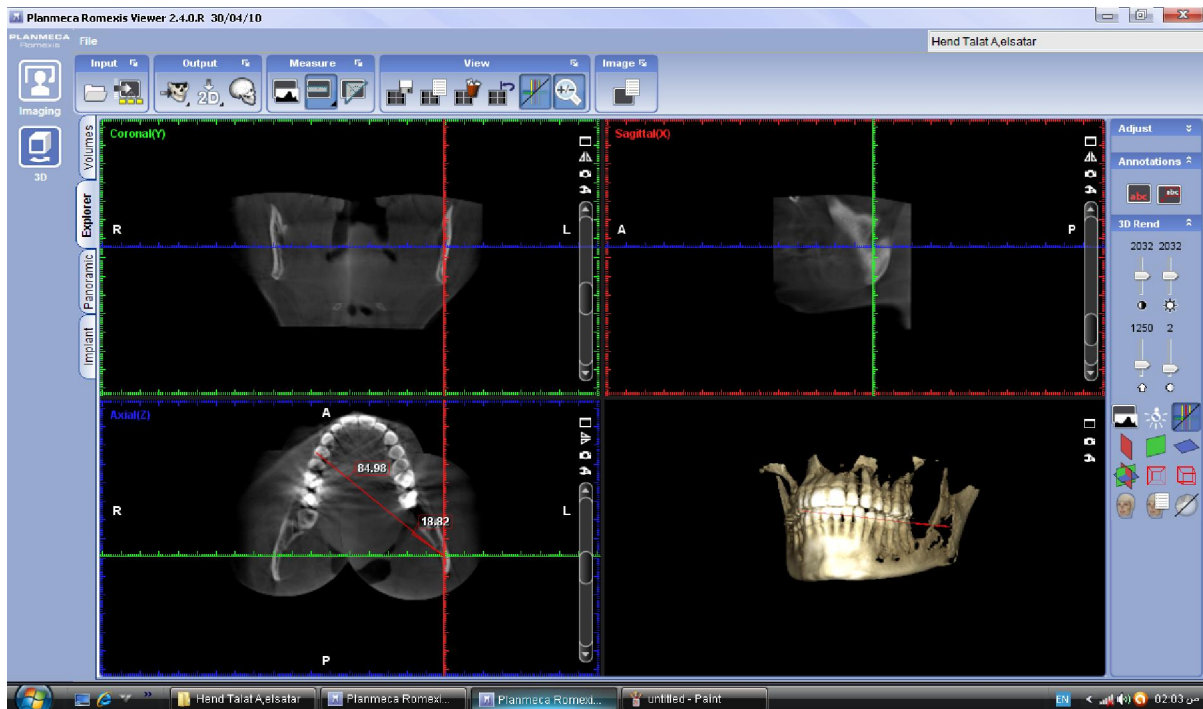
The location of the mandibular foramen is determined in different planes (coronal, sagittal, and axial) of CBCT scans to measure the path of the needle from the premolar region.
